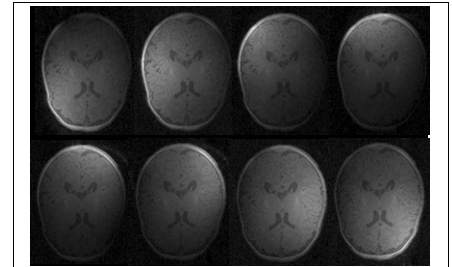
Eight T1 MR images from eight coils. Each image has different coil sensitivity, corresponding to the eight locations of coils placed.
